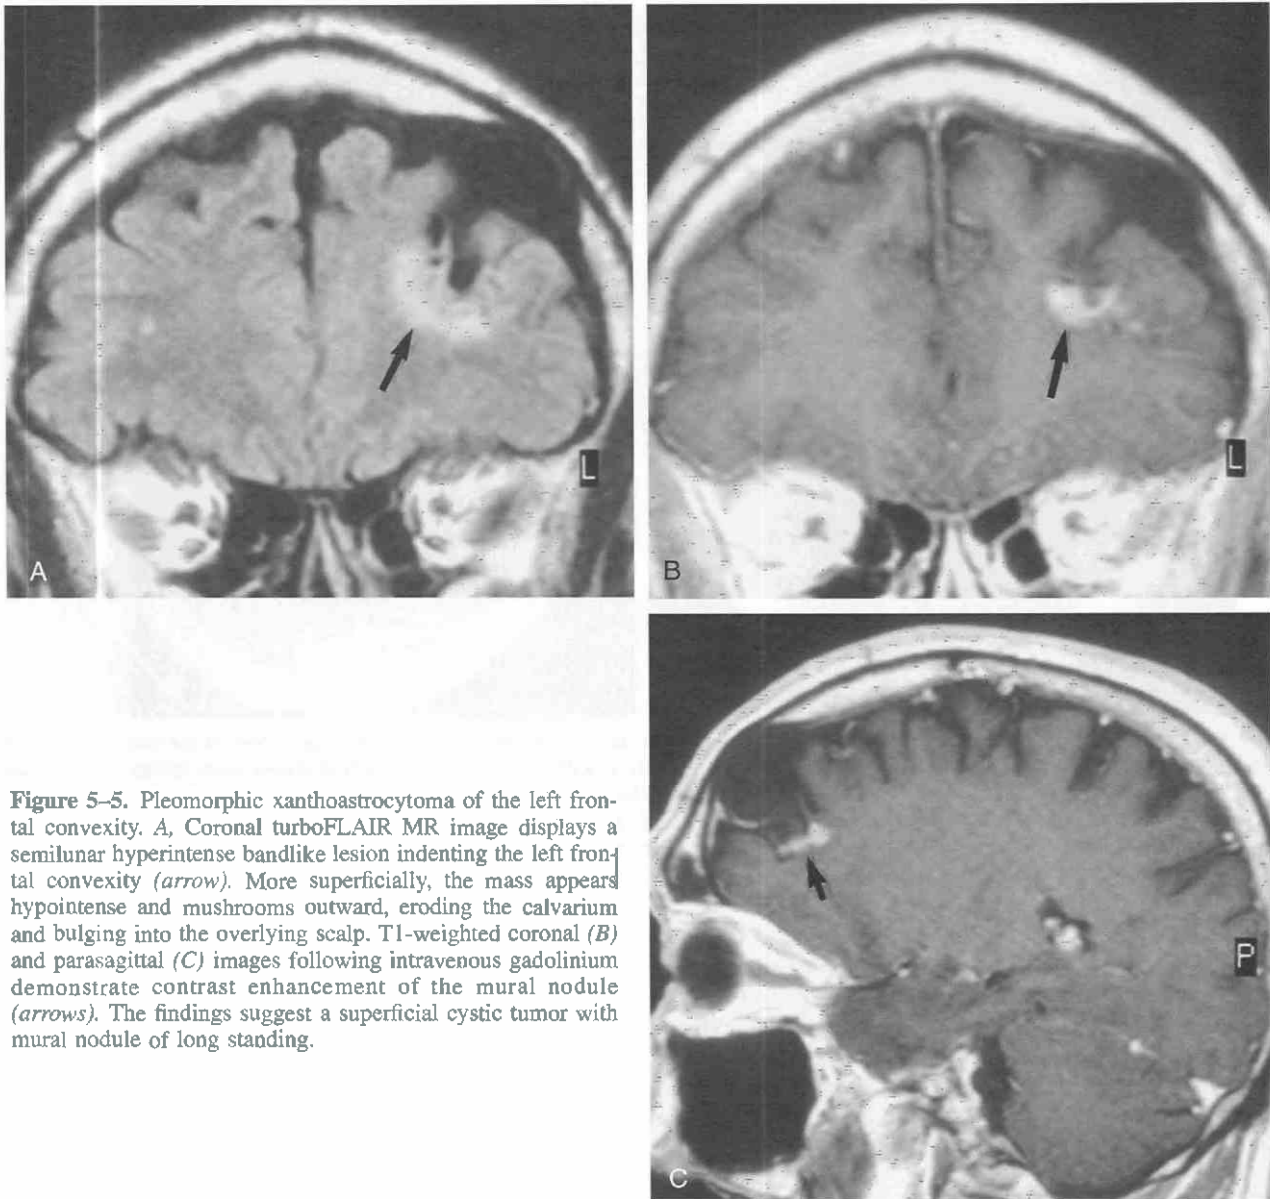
Pleomorphic xanthoastrocytoma of the left frontal convexity. A, Coronal turboFLAIR MR image displays a semilunar hyperintense bandlike lesion indenting the left frontal convexity (arrow). More superficially, the mass appears hypointense and mushrooms outward, eroding the calvarium and bulging into the overlying scalp. T1-weighted coronal (B) and parasagittal (C) images following intravenous gadolinium demonstrate contrast enhancement of the mural nodule (arrows). The findings suggest a superficial cystic tumor with mural nodule of long standing.
